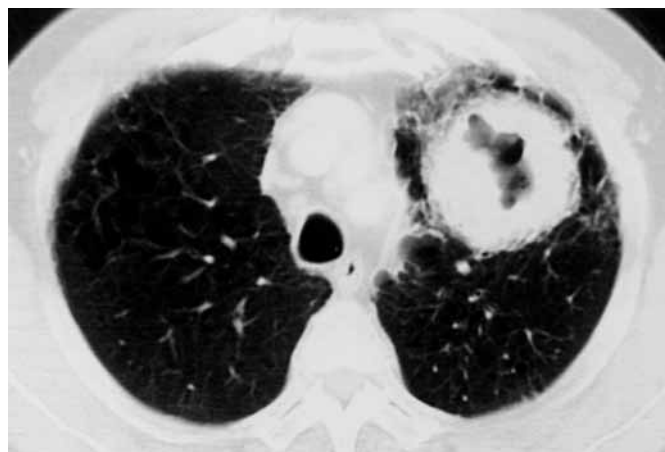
A computed tomography of his chest showed a well-defined cavitating mass in the left upper lobe of the lung.
